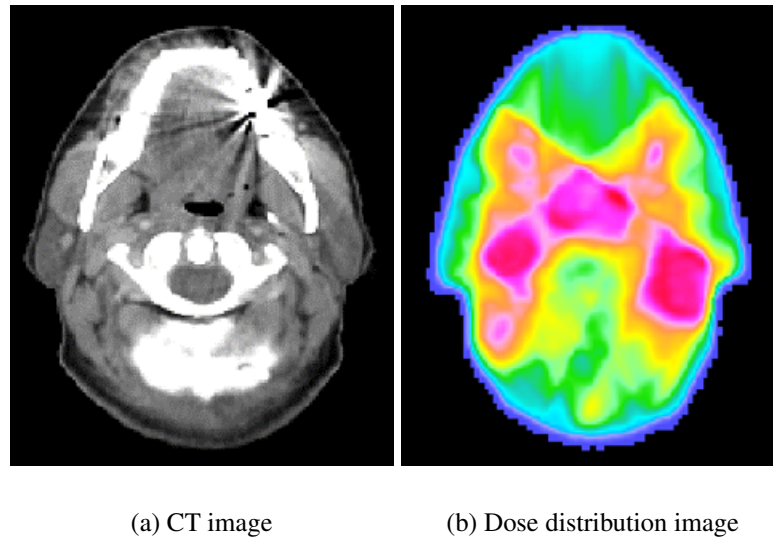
An example of (Right) the planned dose distribution image from (Left) its original CT image.
